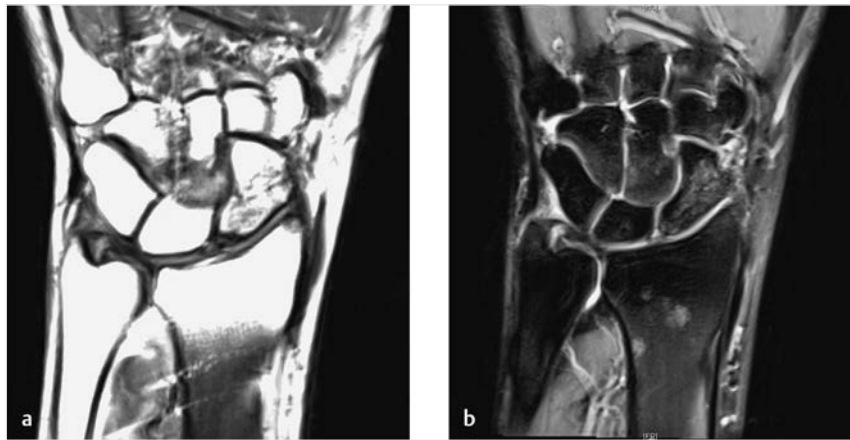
(a, b) Twenty-two-month postoperative MRI suggested that the proximal pole blood supply had been restored with no evidence of avascular necrosis, and preservation of the articular cartilage.
